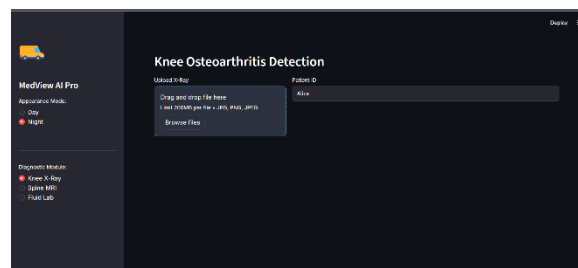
Knee osteoarthritis detection interface with uploaded X-ray.
